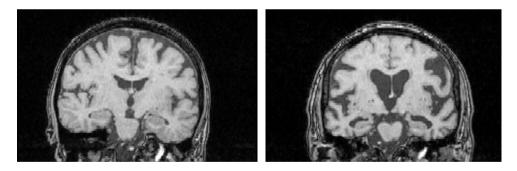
MRI images of MTL and hippocampus during healthy aging (left) and preclinical dementia (right), from participants (78yo, male) involved in SNAC-K.
